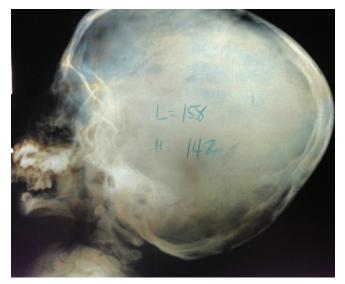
Skull x-ray of Patent 2 showing hypoplastic mandible.
